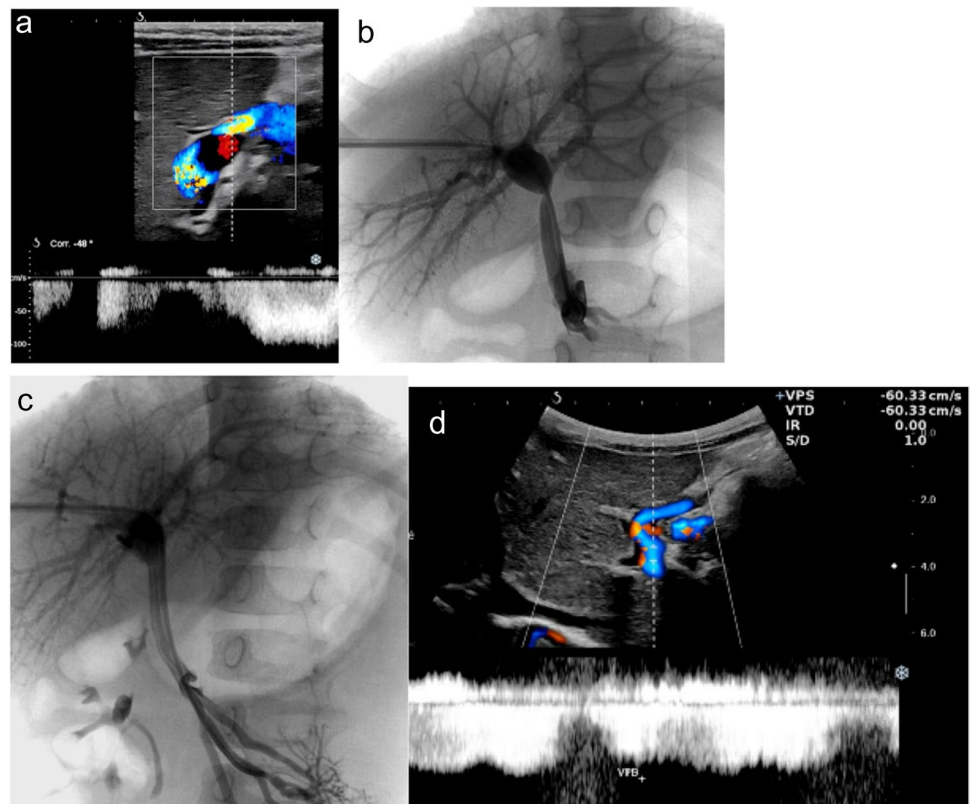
Meso-Rex bypass morphology and flow on colour Doppler ultrasound in a 9-year-old boy. a Anterior sagittal view shows the venous graft (arrow) surgically anastomosed to the Rex recess of the left portal vein (arrowhead) at the level of the ligamentum teres. b
